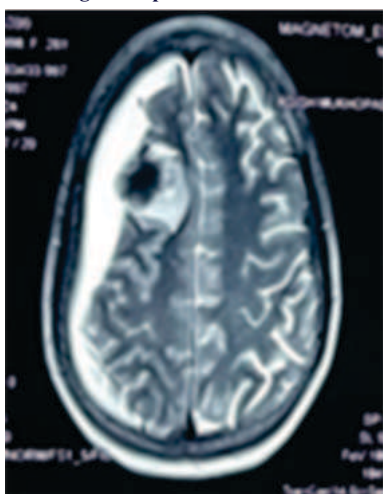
MRI T2w Image Pre-op
